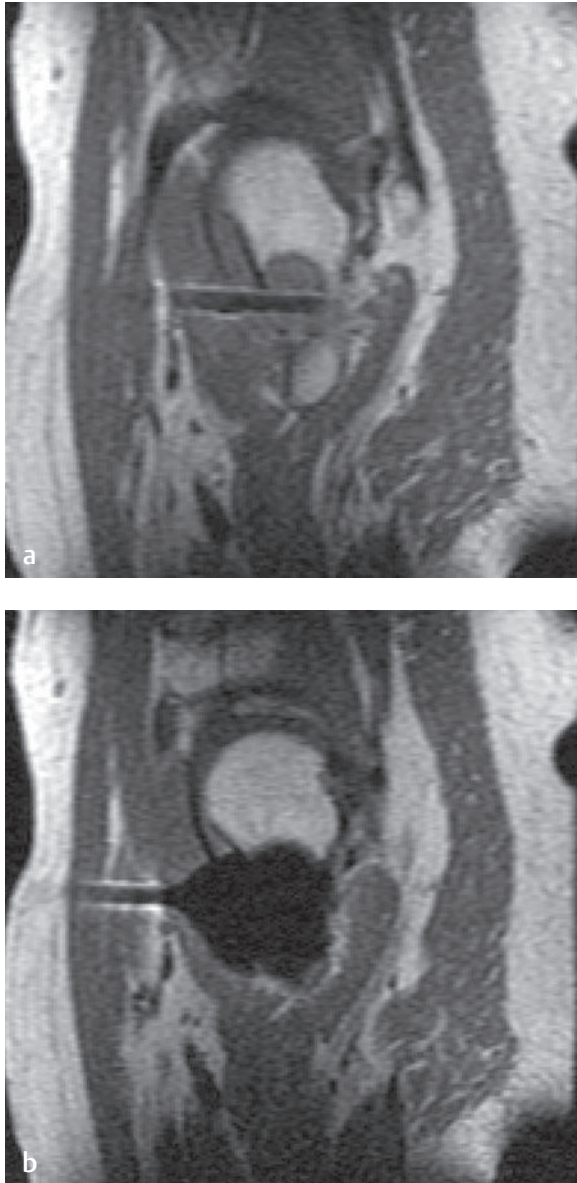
Interventional MRI: cryotherapy. This 50-year-old man had renal cell carcinoma metastatic to the proximal right femur. (a) A sagittal T1-weighted image shows a cryotherapy needle in the hypointense metastasis in the region of the right lesser trochanter. (b) A sagittal T1-weighted image shows an elliptical signal void of the ice ball, representing the treatment zone. Critical structures avoided were the femoral nerve, femoral vessels, and iliopsoas tendon attachment.[†]
